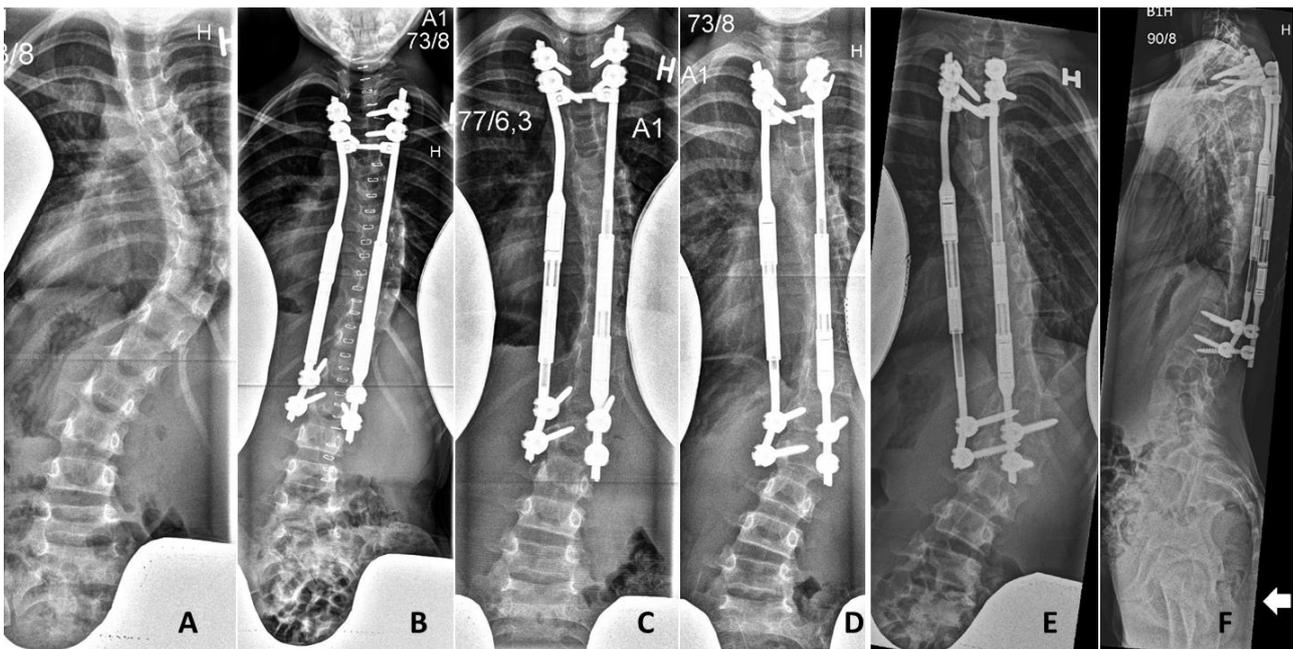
The first patient operated with magnetically controlled growing rods at our center. An 8-year-old girl with idiopathic EOS and a preoperative major curve angle of 77°. Radiographs shown are preoperative (A), postoperative (B), at 1.5-year (C), 3-year (D) and 4.5-year postoperatively, antero-posterior (E) and lateral (F). Postoperatively, major curve was reduced to 41°. After 1.5 years she developed pain at the distal anchor site. A CT-scan showed screw loosening and she was re-operated with exchange of both rods. She had undergone 27 distractions at latest radiographic follow-up and total achieved distraction was 53.2 mm on the concave rod and 36.5 on the convex rod. T1T12 and T1S1 increased from 199 mm and 326 mm preoperatively, to 235 mm and 366 mm at 4.5-year follow-up, respectively. She just had her menarche at the latest follow-up.
